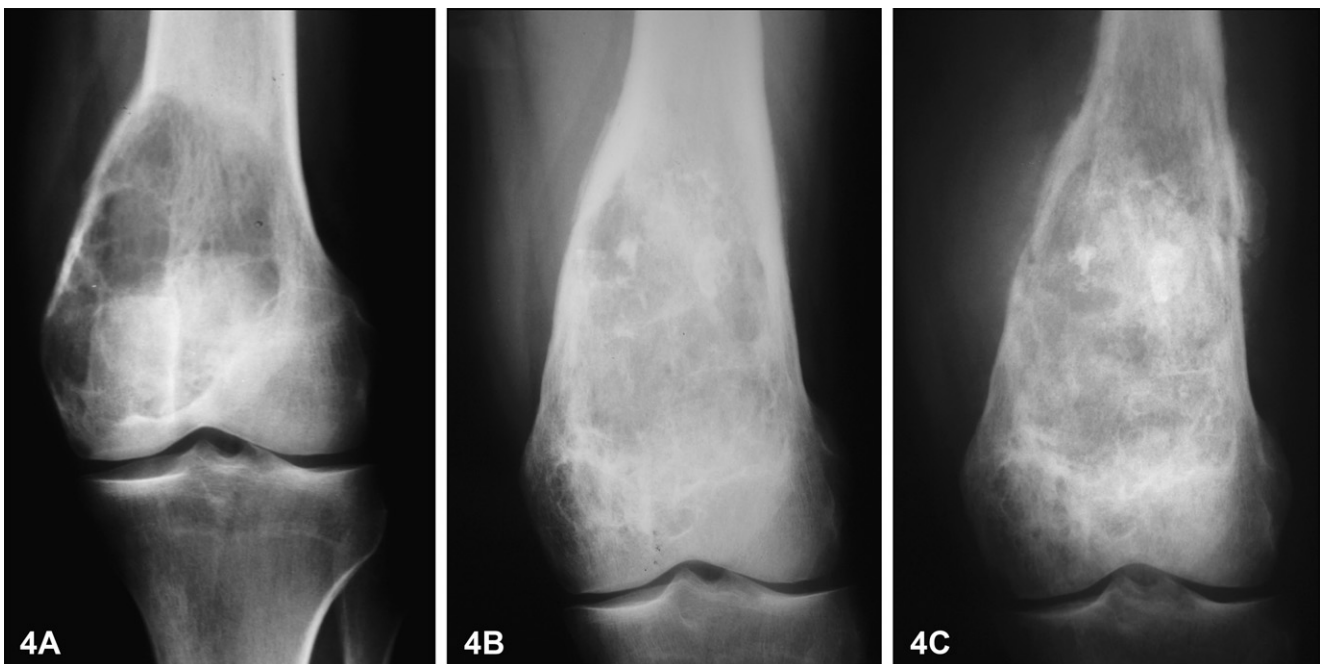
Case 6: AP radiographs. (A) Giant cell tumor, after curettage and grafting with autogenous bone, June 1976. (B) and (C) Malignant Fibrous Histiocytoma in July 1991 (hardly visible limited osteolysis) and September 1991 (massive lytic lesion), respectively.
